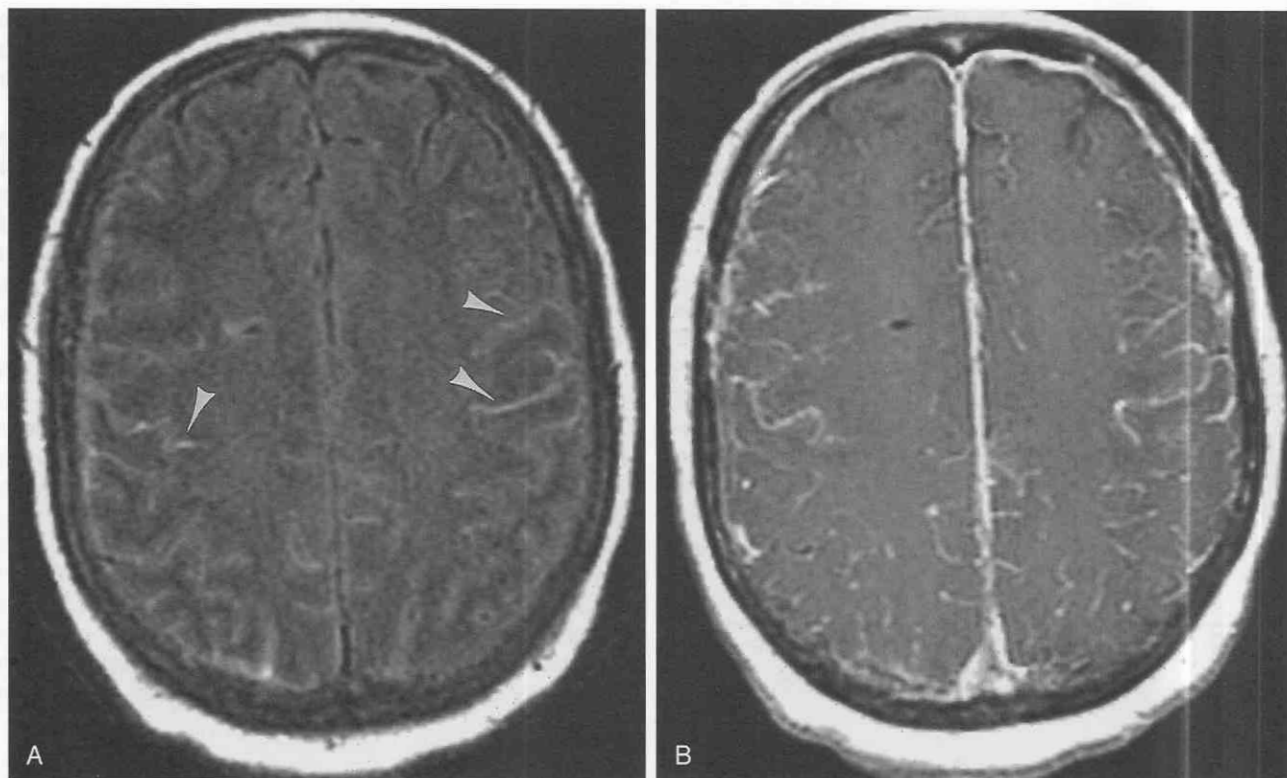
Axial fluid-attenuated inversion recovery (FLAIR) image in a patient with leptomeningeal spread of breast carcinoma (A) shows signal abnormality in a pia/subarachnoid space pattern (arrowheads) that enhances on the T1-weighted image after administration of gadolinium (B).
